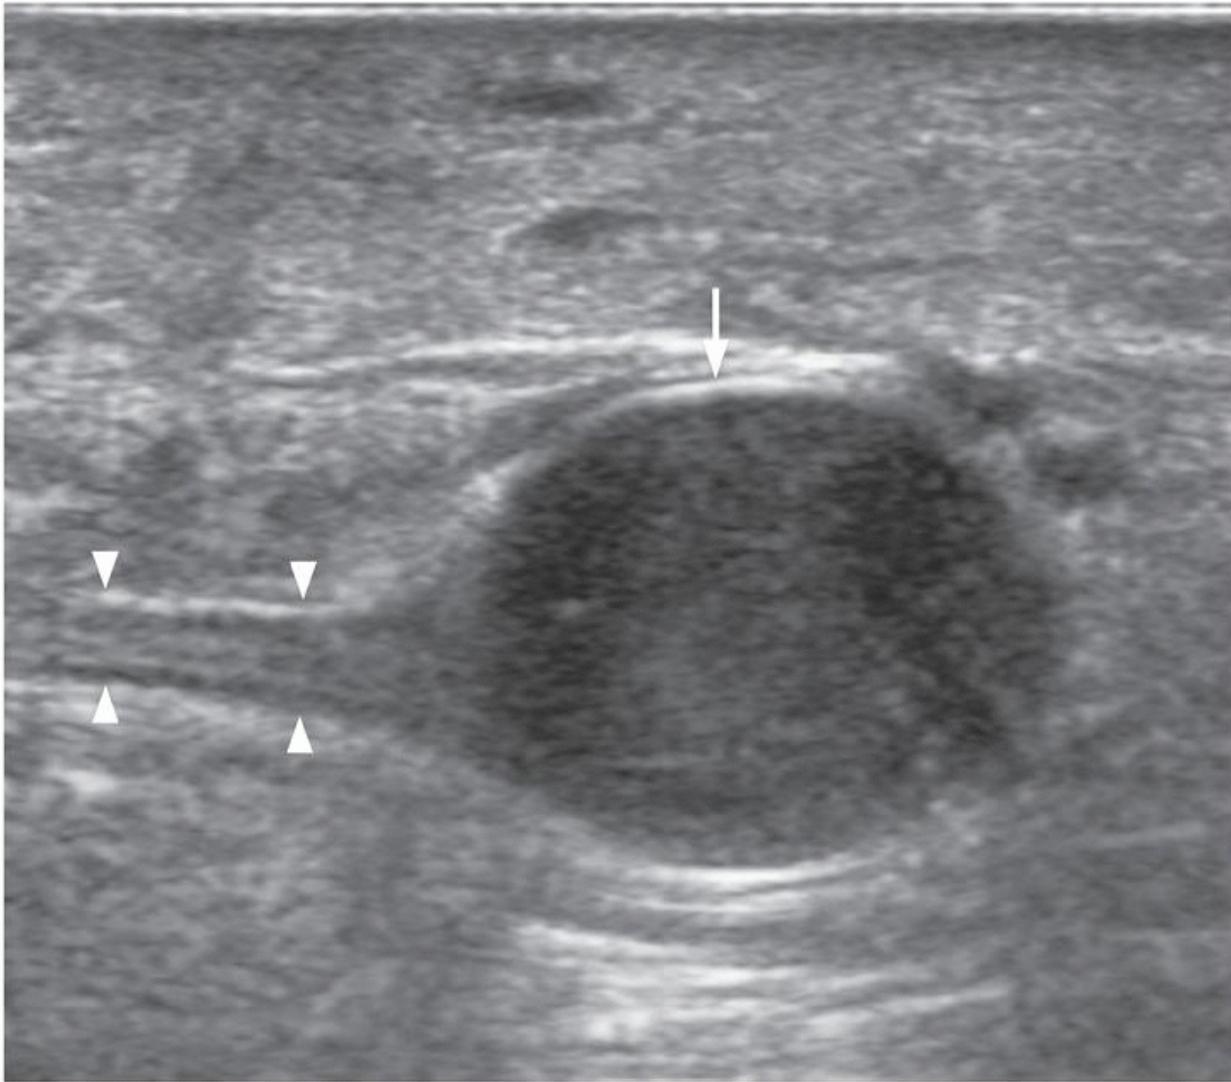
Longitudinal ultrasound of medial ankle showing a nerve sheath tumor (arrow) of the tibial nerve. The thickened entering nerve is shown (arrowheads). The exiting nerve is not visible in this image plane.
